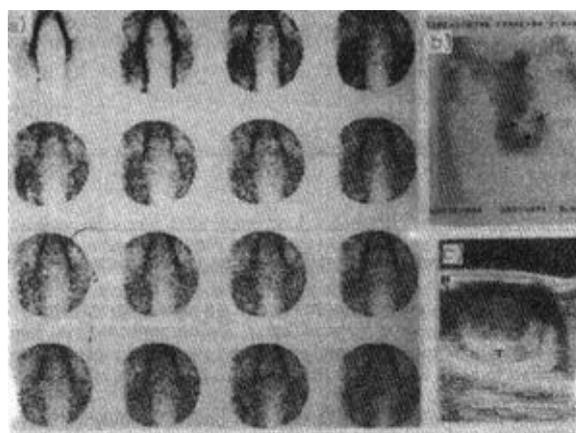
Seminoma. Normal perfusion (a), hypoactive area in static image (b), hypoechoic solid mass in ultrasonography (c).
